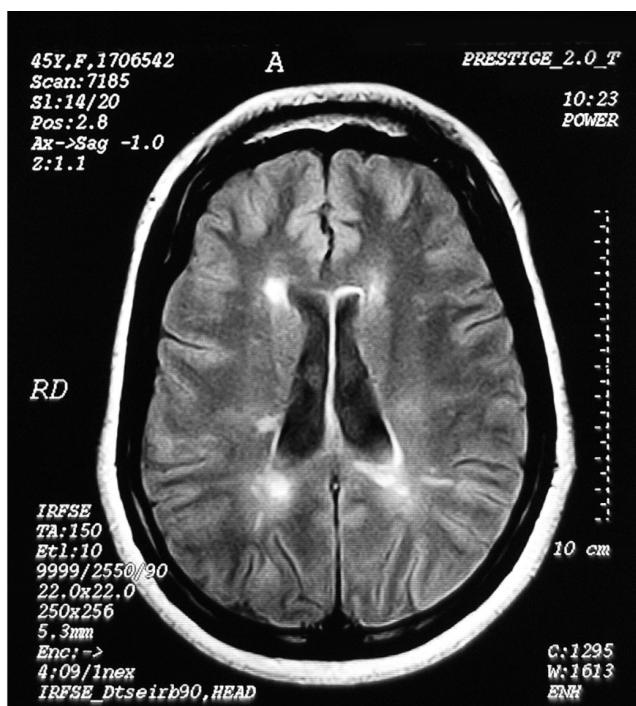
Brain MRI axial section, showing demyelinating periventricular lesions in a patient presenting bipolar disorder and multiple sclerosis.
